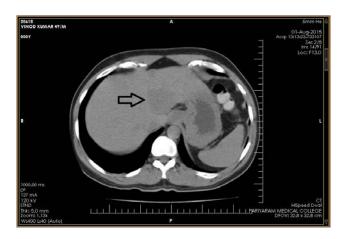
Plain CT showing hypodense lesions in the liver
